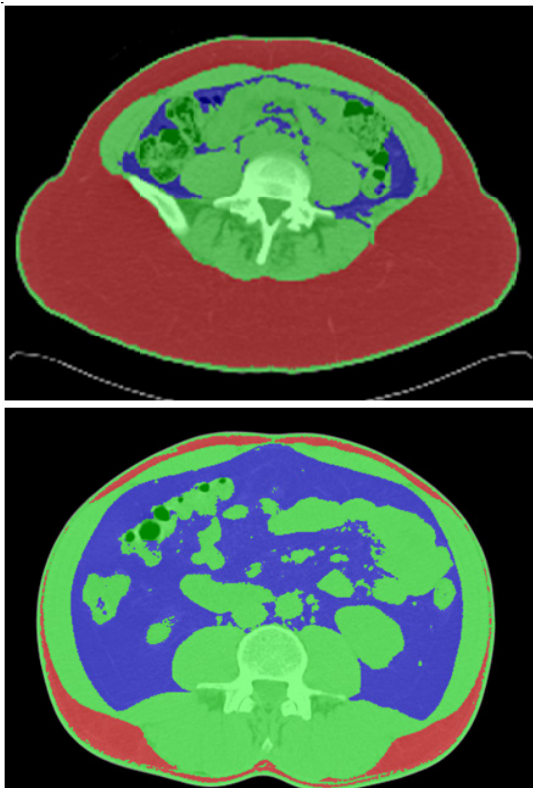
Abdominal CT images courtesy of M. Puyanitya, Image Reading Center, New York, NY showing two individuals with similar waist circumference but different levels of visceral adipose tissue. Red area on image = subcutaneous fat, blue area on image = visceral adipose tissue.
